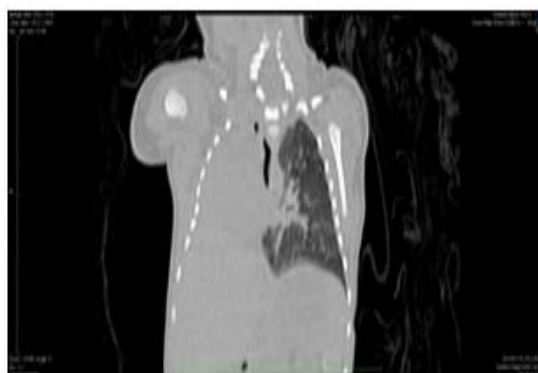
CT Axial Coronal Image in lung window. Mediastinum is displaced towards the right side.
